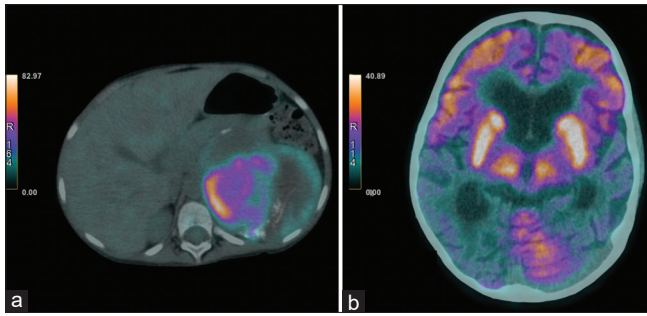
Axial FDG-PET/CT image showing left-sided adrenal origin calcified, solid, cystic mass with calcifications and FDG uptake in the solid component diagnosed as ACC (a) bilateral increased tracer uptake in frontal-temporal lobe and basal ganglia with decreased uptake in parietal-occipital lobes. (b) FDG-PET/CT: Fluorodeoxyglucose-positron emission tomography/computed tomography, ACC: Adrenocortical carcinoma
